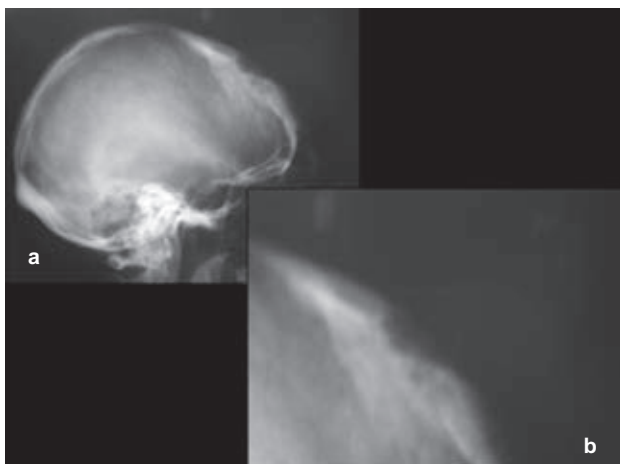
a. Simple cranial X-ray showing a left frontal lytic lesion. b. Close-up to the lytic lesion.
